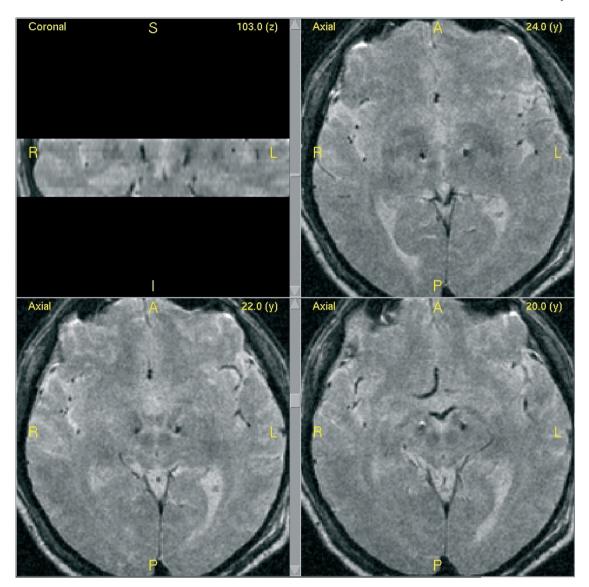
The subthalamic DBS electrode location. Postoperative imaging showing electrode location in one representative male patient. CT postoperative scans were fused with preoperative T_2 weighted MRI scans. (Top) Coronal section (left panel) and axial section 24 mm (right panel); (bottom) axial sections (y = 22 mm, left panel; y = 20 mm, right panel). Note that the electrode locations correspond to the STN area. Images were obtained by the software 'Radionics, image fusion 2.11'.
